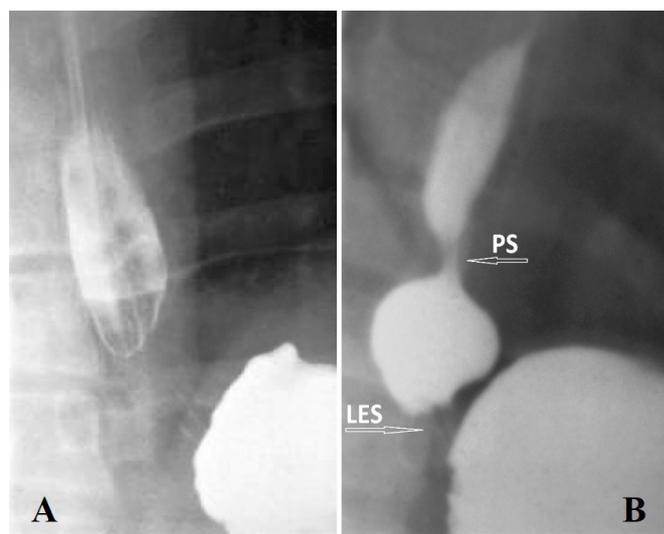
(A) X-ray picture of the GEJ of a patient with a GERD. There is a contraction of the LES during the abdominal compression, which caused the barium bolus to stop moving. The length of the gap between the barium-containing esophagus and the stomach is a LES contraction. (B) The child aged 7 with GERD. Compression of the abdomen during the reception of barium led to a contraction of LES. Its length is 0.7 cm (the norm for this age is 1.5-1.9 cm). The proximal sphincter closes the phrenic ampulla to create a threshold pressure and to open the LES
